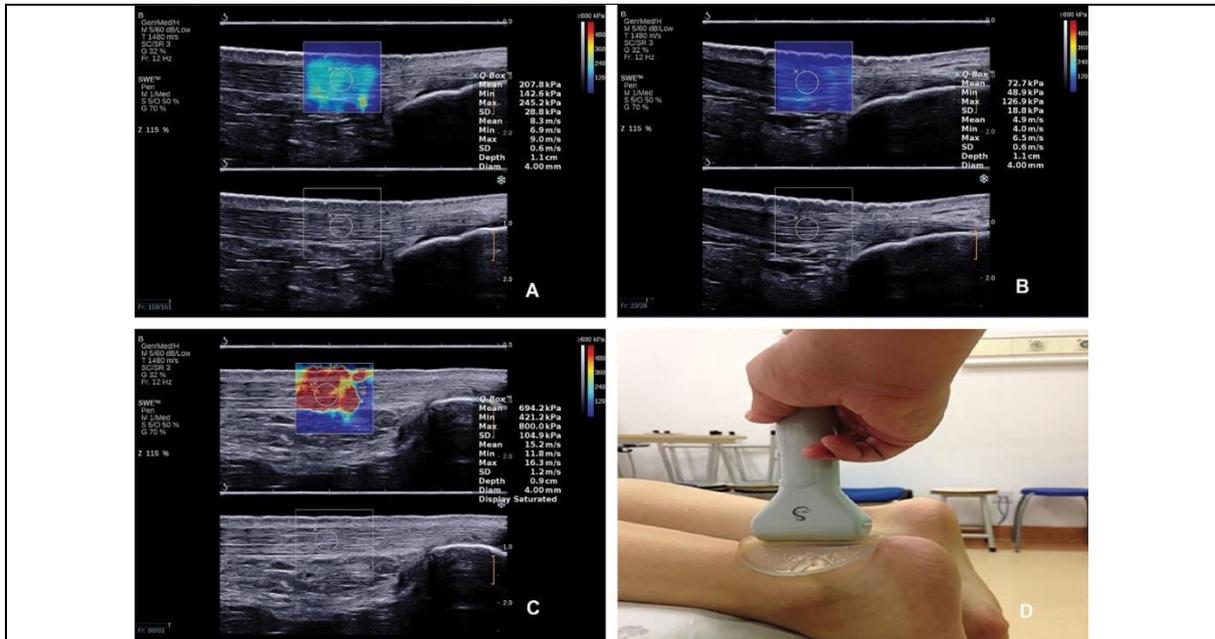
Shear Wave Ultrasound Elastographic evaluation of Achilles Tendon
